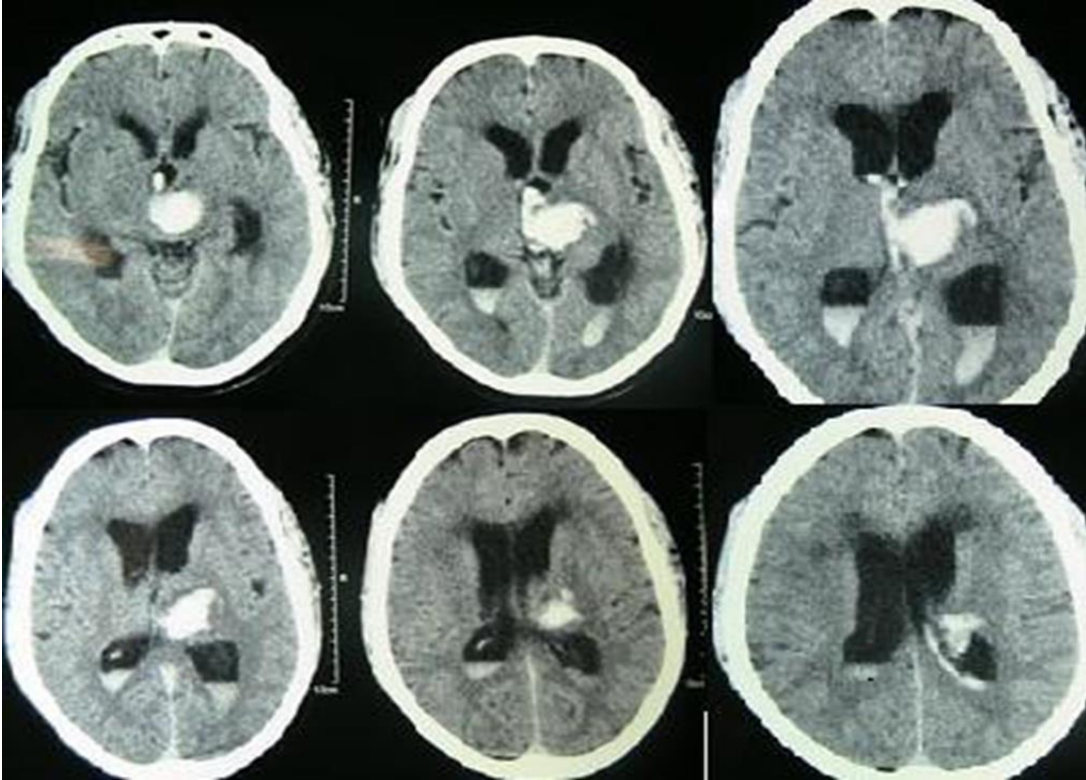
CT images of intracerebral hemorrhage. Image adapted from BMC Neurol 7; 1(2007). (open access)
